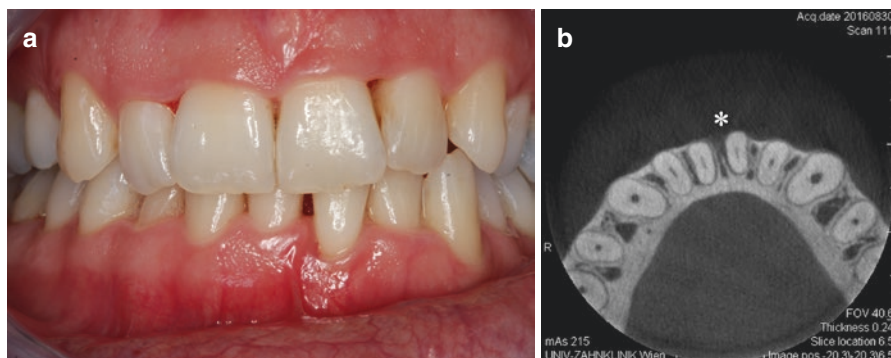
(a) Thick periodontal biotype, buccal position of #31, clinical signs of inflamed gingiva, 1.5 mm buccal recession, loss of interdental papilla, PPD 5 mm on mesial aspect, high frenum insertion #41; (b) CBCT of area of interest #31: note demineralized interdental bone
